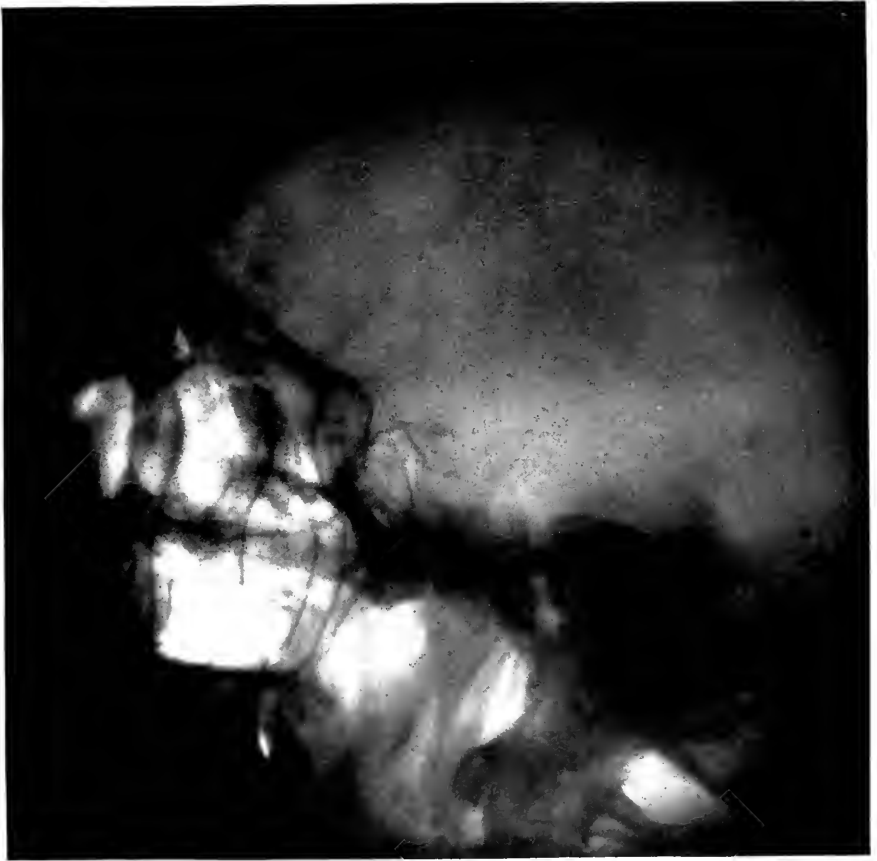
X-ray showing excavation and bone rarefaction in ant. and mid. cranial fossae. Deformation of ant. clinoid processes.
